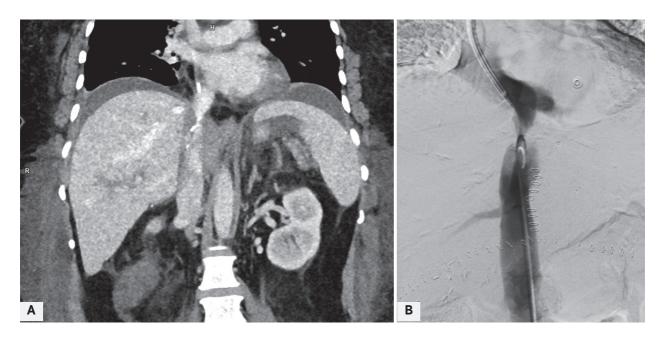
(A, B) Coronal MPR Computed Tomography Image and Venacavography Showing Prominent Narrowing at the Anastomotic Site of Deceased-Donor Liver Transplant Recipient
